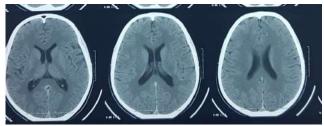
CT scan of brain showing Prominent ventricles and external CSF space.
